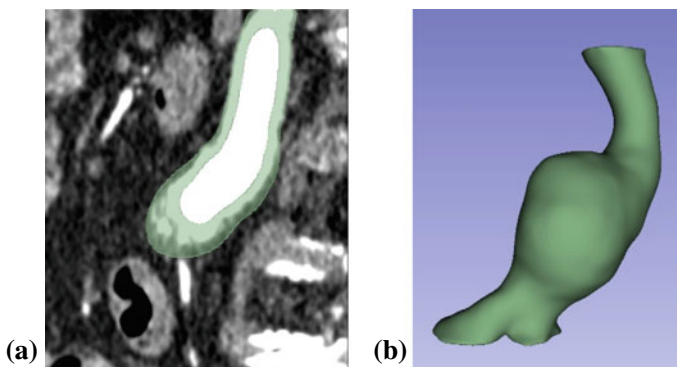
AAA wall extraction—a CT image of AAA wall segmentation viewed in sagittal plane; b 3D label reconstruction of AAA wall. Viewed in 3D Slicer
